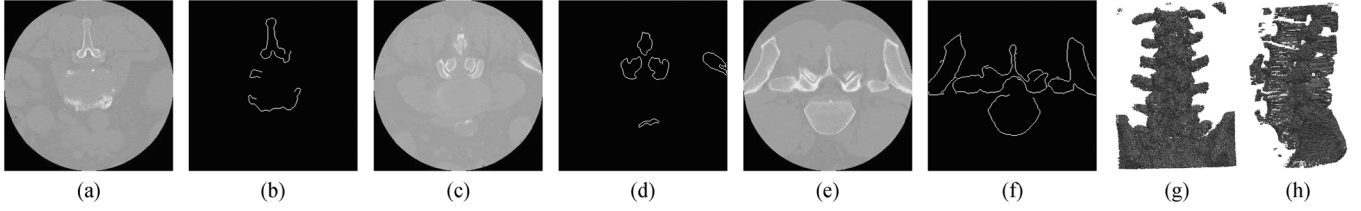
(a)–(f) Example of results obtained with the Canny edge detector on sample CT images of spine. (g) and (h) Volume rendering of a typical result from the Canny edge detector.
